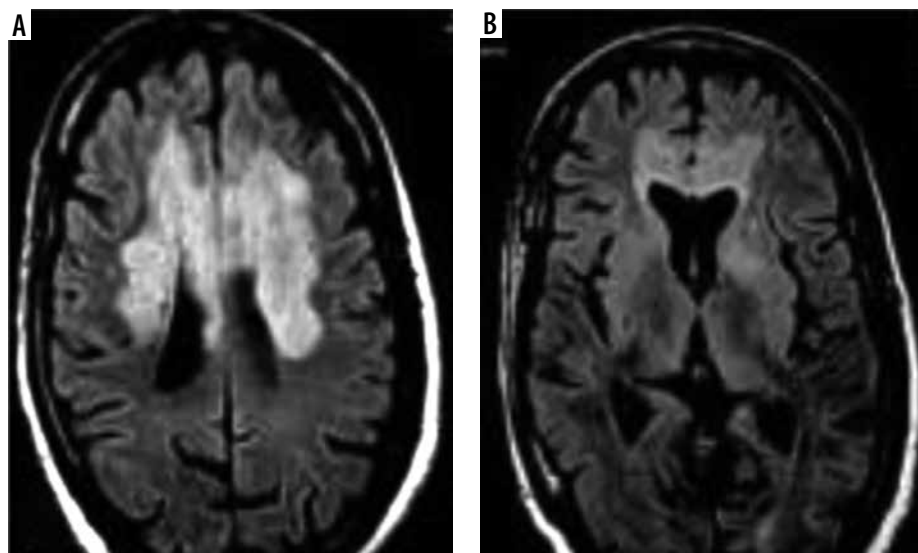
Axial FLAIR images of a 57-year-old male patient with MERS-CoV. Results showed bilateral confluent subcortical areas and deep white matter hyperintense lesions in the frontal lobes, basal ganglia, and corpus callosum
